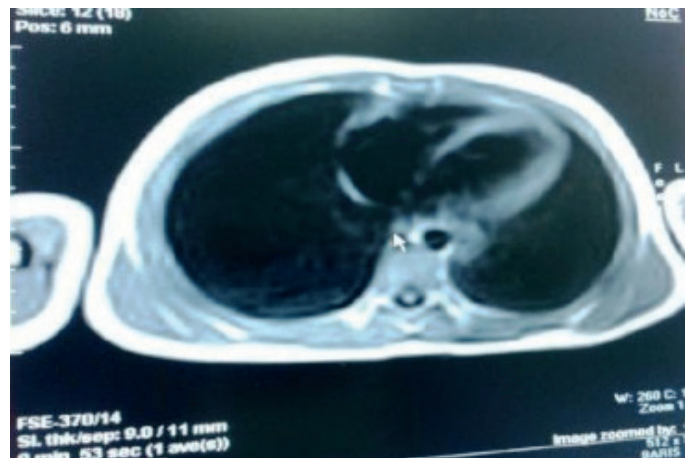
Regression of high signal areas with T2 images of mediastinal magnetic resonance imaging on mediastinum subcarinal area from thoracoabdominal junction towards the left paraaortic field (on 2 weeks of the treatment)
